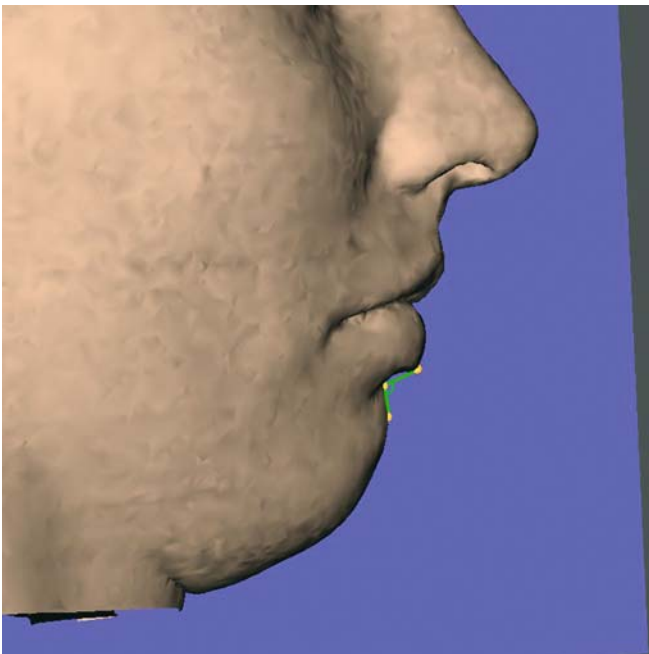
The labiomental angle, $li-sl-pg$, is a projected angular soft tissue measurement on the median (z) 3-D cephalometric reference plane (3-D CT, soft tissues, patient K.C.)
